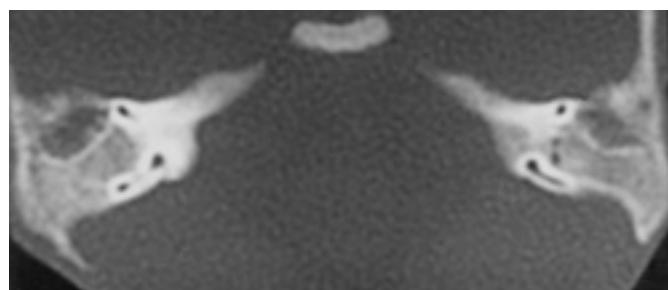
Bilateral unpneumatized mastoid bones on temporal CT.
